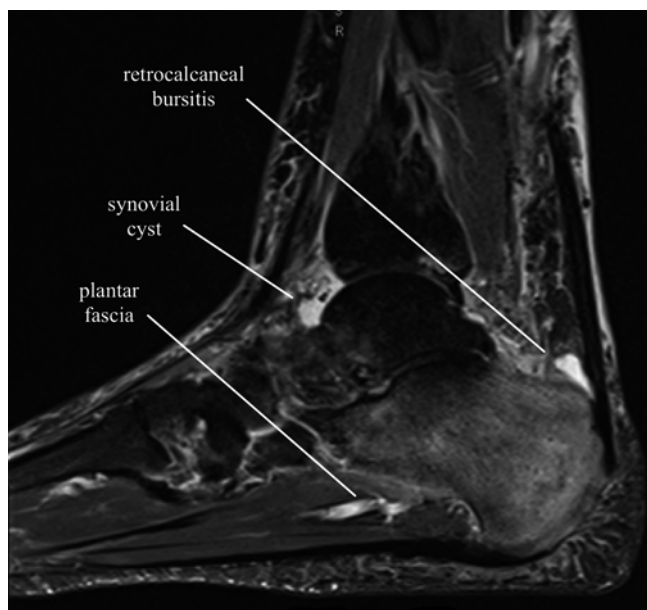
STIR MRI sagittal image of the ankle showing retrocalcaneal bursitis, a synovial cyst, and plantar fascial irritation (Image courtesy of Andrea Trescot, MD)
